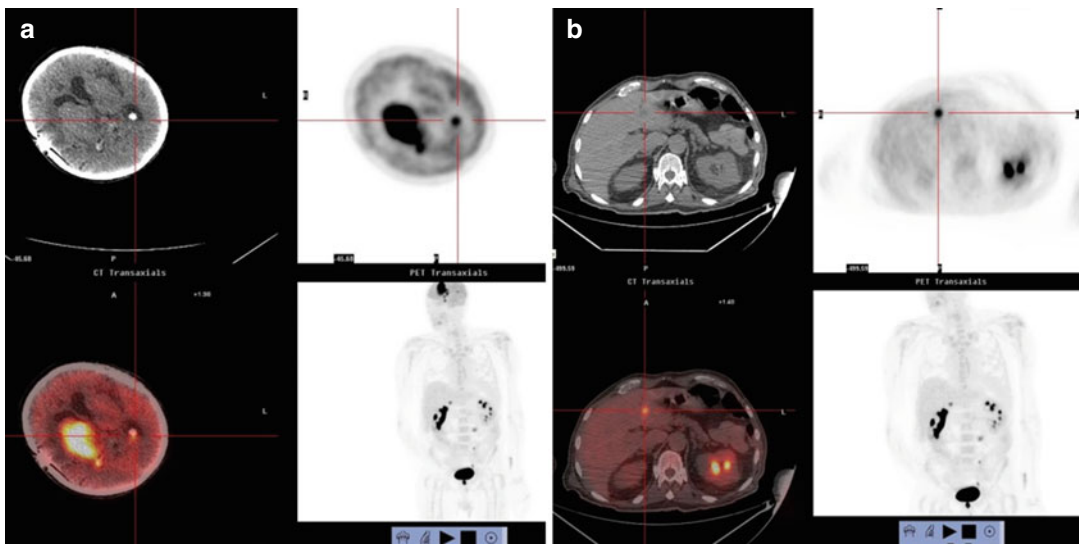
(a) Abnormal FDG uptake in the periventricular area of the right brain hemisphere (SUVmax 28) and in the calcified choroid plexus of the occipital horns of the lateral ventricles. (b) Abnormal uptake is seen in segment III of the liver (SUVmax 10)
